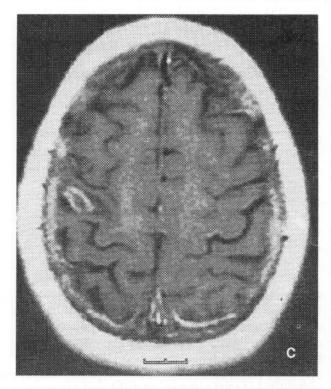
MRI images of a tumor for which repeat radiosurgery is performed.
